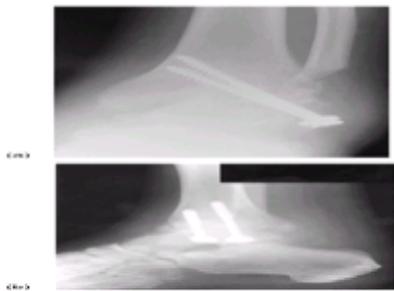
Anteroposterior (a) and lateral (b) radiographs showing an ankle joint arthrodesed using parallel screws. The subtalar joint is normal.
